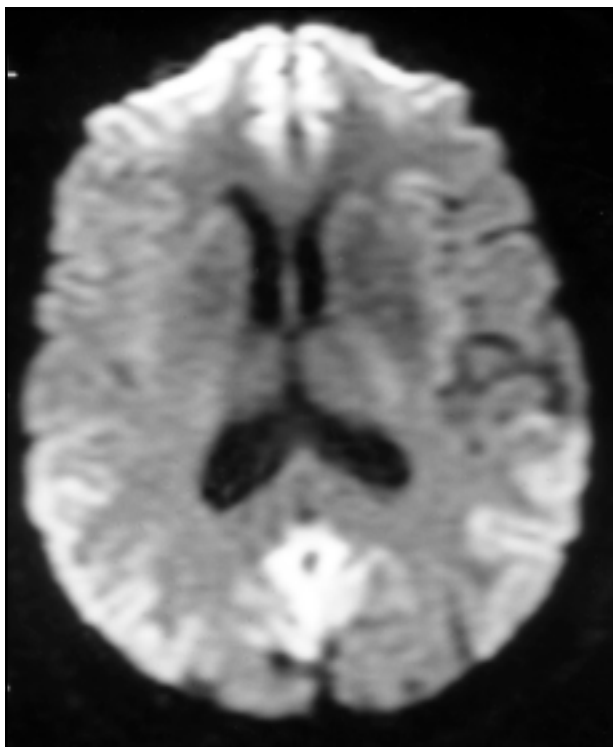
Axial DWI (TR/TE 9999/92.6), approximately at the same level as the previous image, depicts unequivocal hyperintense signal in the frontal, temporal and occipital cortices bilaterally. The basal ganglia and thalamus are spared.
